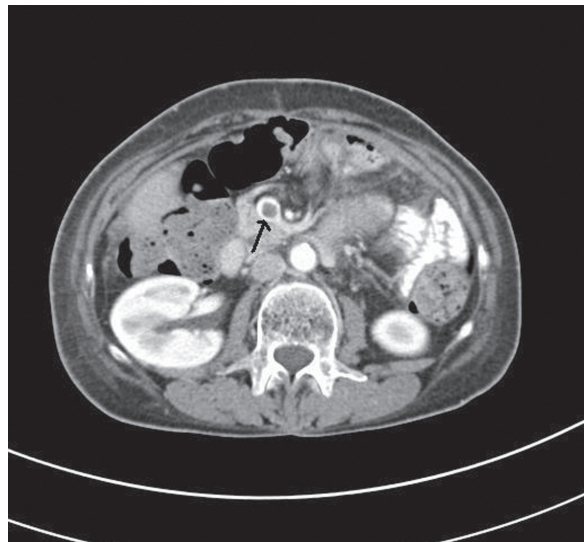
Abdominal computed tomography demonstrating an old thrombus (arrow) in the superior mesenteric vein.
